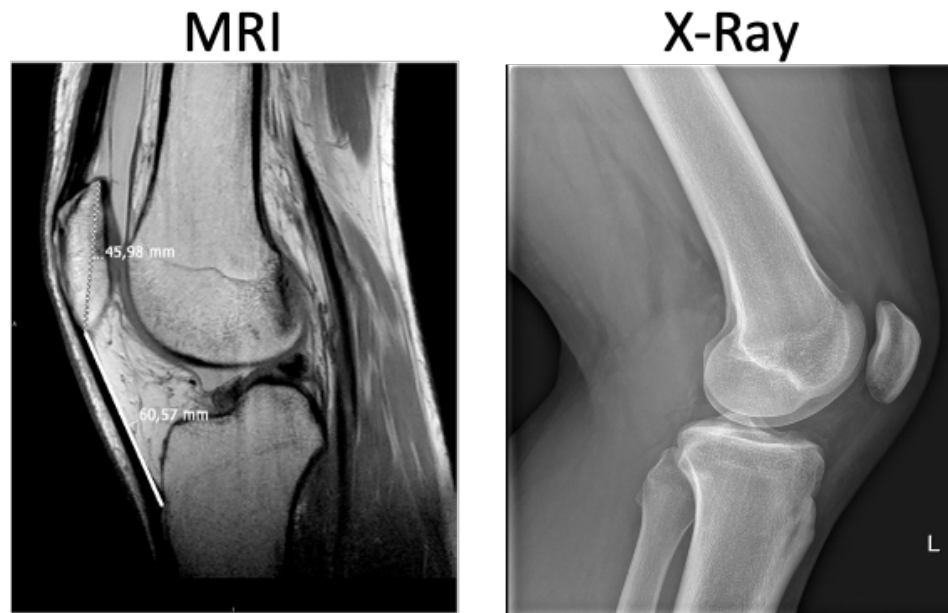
Figure Error! No text of specified style in document..1: Examples of Current Diagnostics Available. MRI (left) and X-ray (right) are the main tools available for clinical diagnosis
